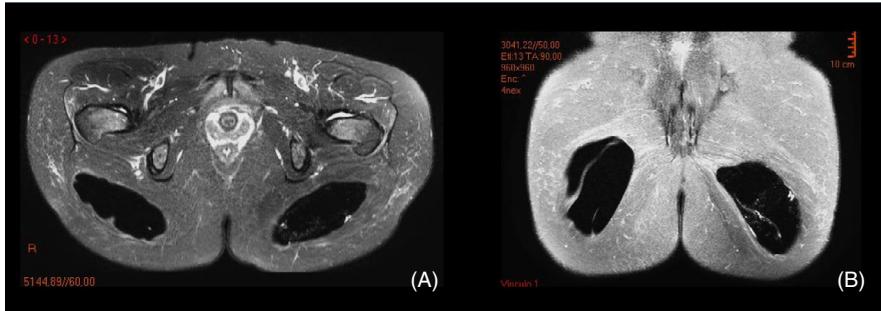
A, Axial and B, coronal T1-weighted postgadolinium image with fat saturation demonstrates the thickness of the fibrous capsule and intracapsular mass, both with contrast enhancement
